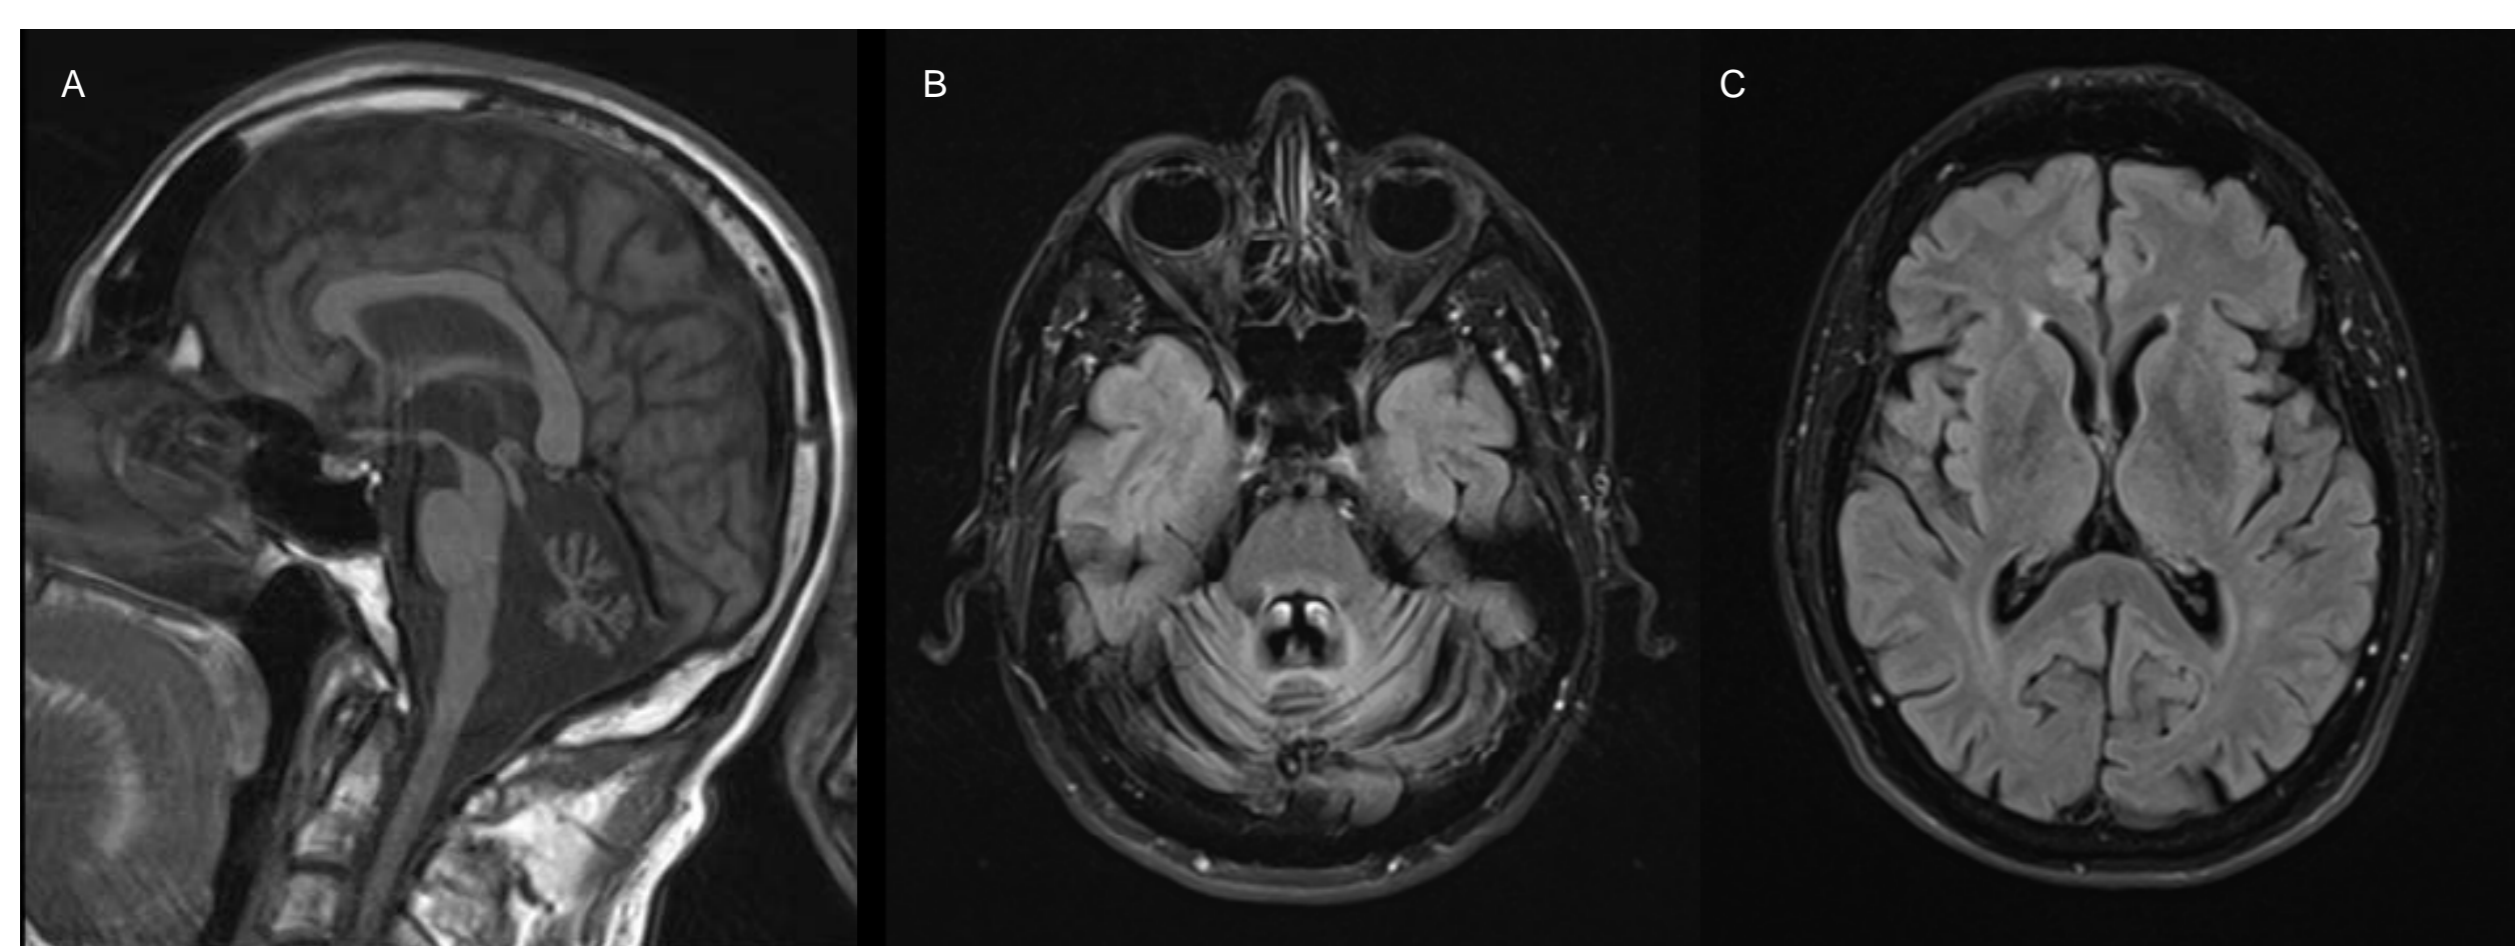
Sagittal T1-weighted (A), axial FLAIR (B-C) images showing important subcortical atrophy of braistem and cerebellar structures (A-B) and mild supratentorial atrophy (C). Absence of white matter signal abnormalities.
